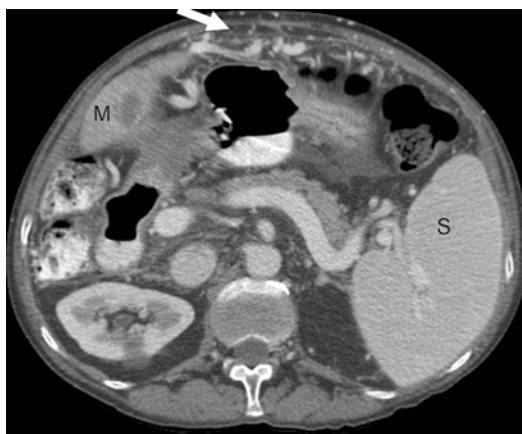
Splenomegaly due to FOLFOX. A 59-year-old male with colorectal cancer metastatic to the liver diagnosed 2 years prior and treated with 23 cycles of FOLFOX. CT scan shows enlargement of the spleen (*S*) and splenic vein with formation of collateral vessels (*arrow*). *M* metastatic disease. Treatment with oxaliplatin causes sinusoidal injury to the liver, leading to portal hypertension, ascites, splenomegaly, and collateral vessels. Small-volume ascites is also seen on both images
